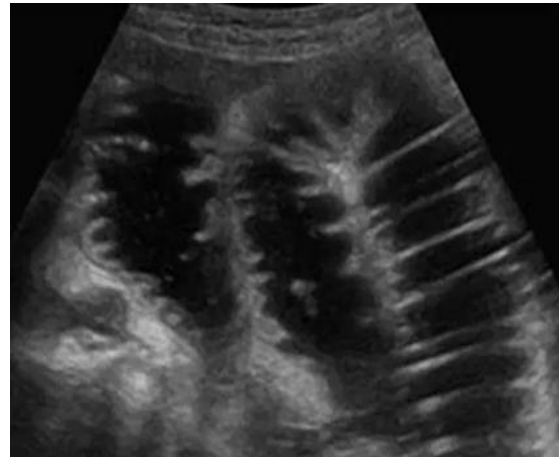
Sonogram of the small intestine filled with water
